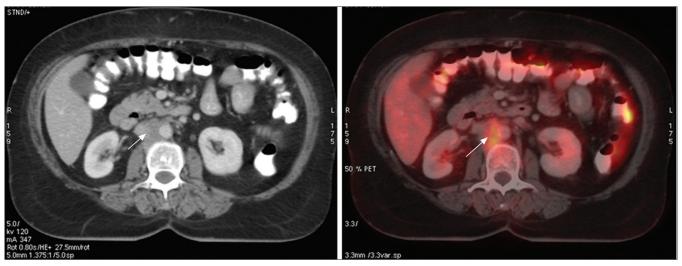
F-18 FDG transaxial images showing soft tissue mass in the aorto-caval region on CT (left) and intense FDG uptake (arrow) on PET/CT fused image (right) in this soft tissue mass in the abdomen
